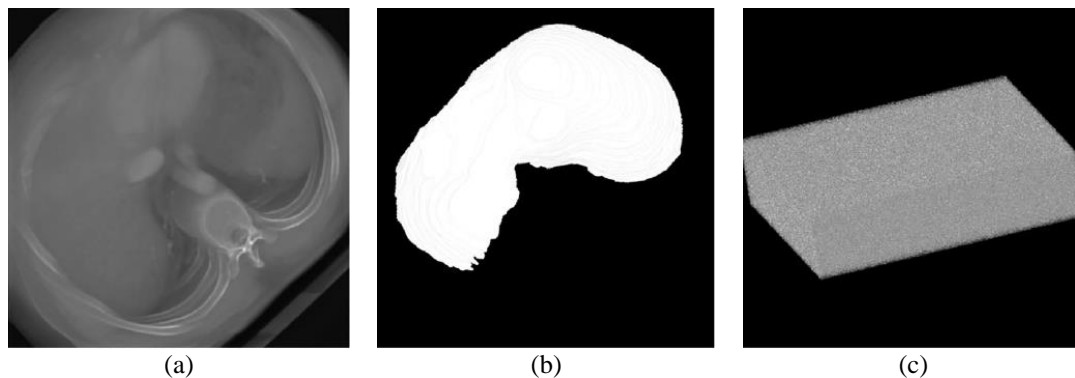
These figure are samples of (a) grey scale image of ICOM CT, (b) segmented binary image of CT, and (c) randomly distributed 3D-image
